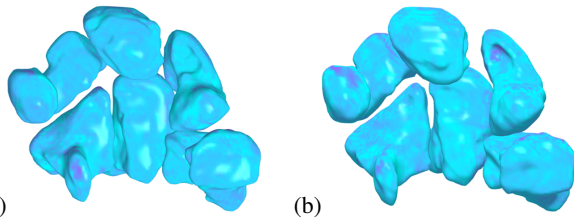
Comparison of the gray-levels mapping between the surface texture of the MRI baseline and (a) the MRI follow-up (b), performed on the follow-up 3D surface. Texture changes locates tissue degeneration and/or an erosion process. Light blue values are associated with darker gray-levels and pink region to brighter intensities.
